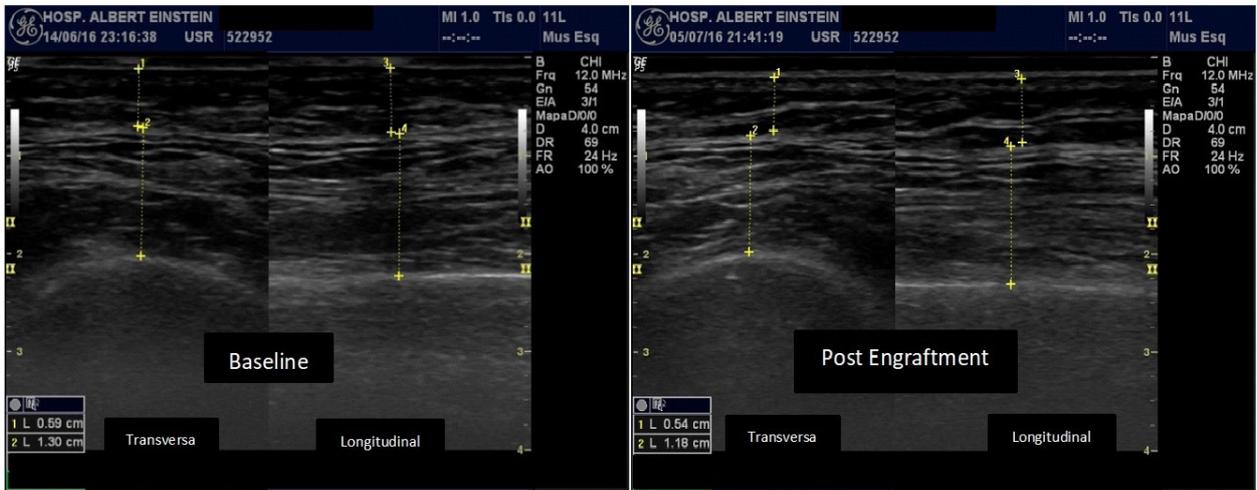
Ultrasound images of right quadriceps femoris muscle in transversal and longitudinal planes. Same male patient in baseline and post engraftment.
